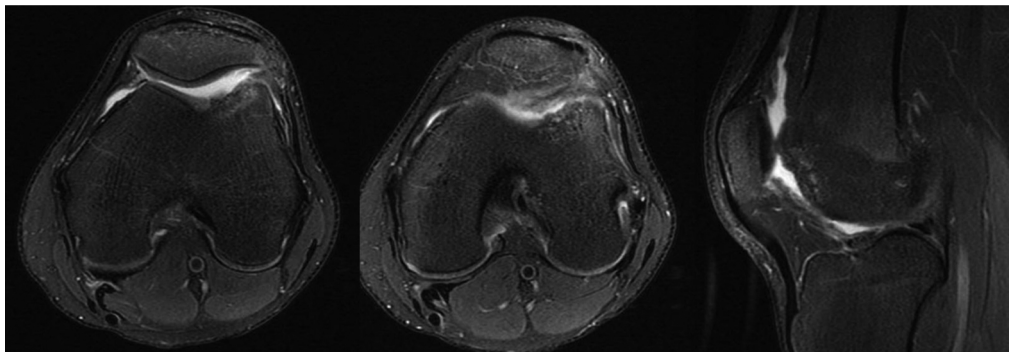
Post-operative magnetic resonance imaging showing bone graft integration, subchondral bone recovery, and early repair tissue formation at the joint surface.
